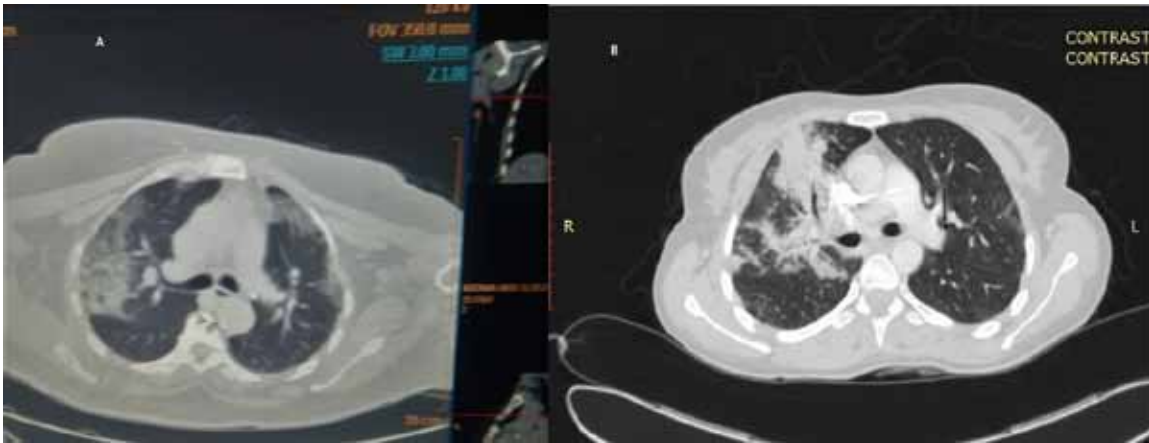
A. COVID-19 positive CT picture of the crazy paving pattern, B. Segmental consolidation in a patient with severe chest infection COVID-19 negative patient
